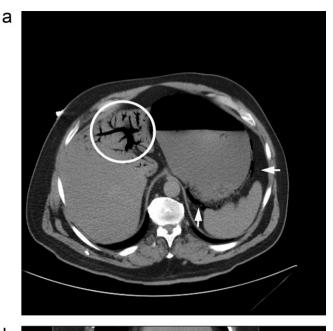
CT scans of abdomen and pelvis (axial first, then coronal views) demonstrating portal venous air (circle) and air within the wall of a distended stomach (arrows).
